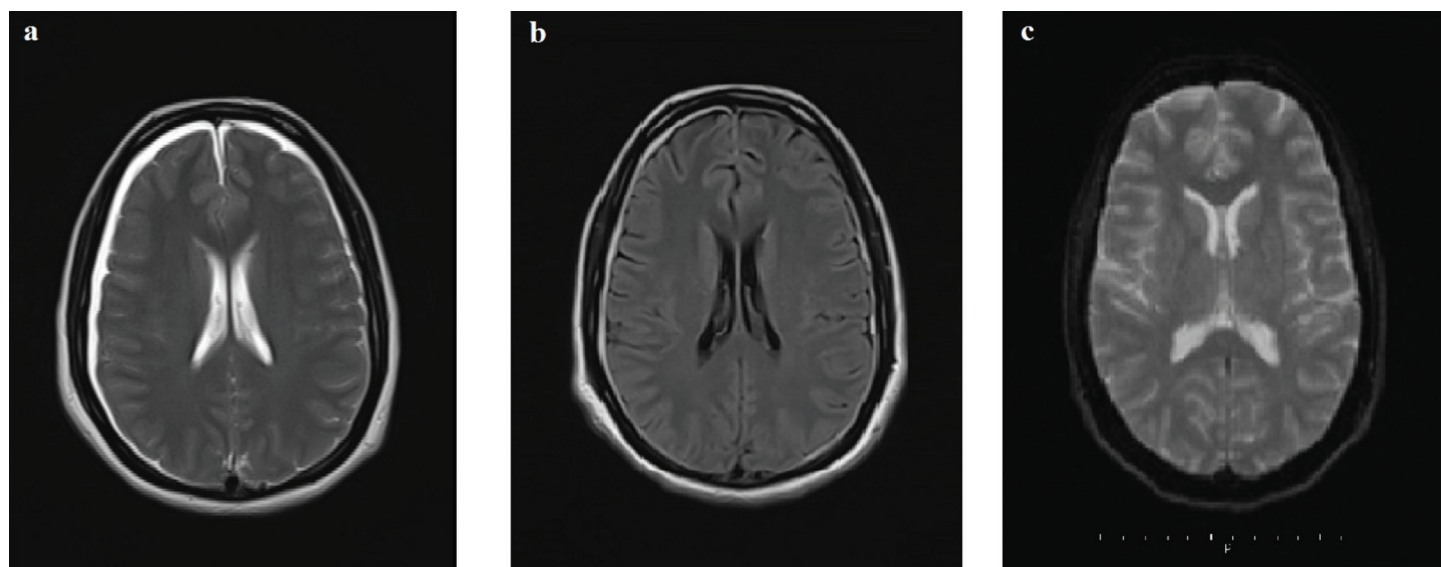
MRI images of the case on the sixth (a), thirteenth (b) and twenty-second (c) day of postpartum
